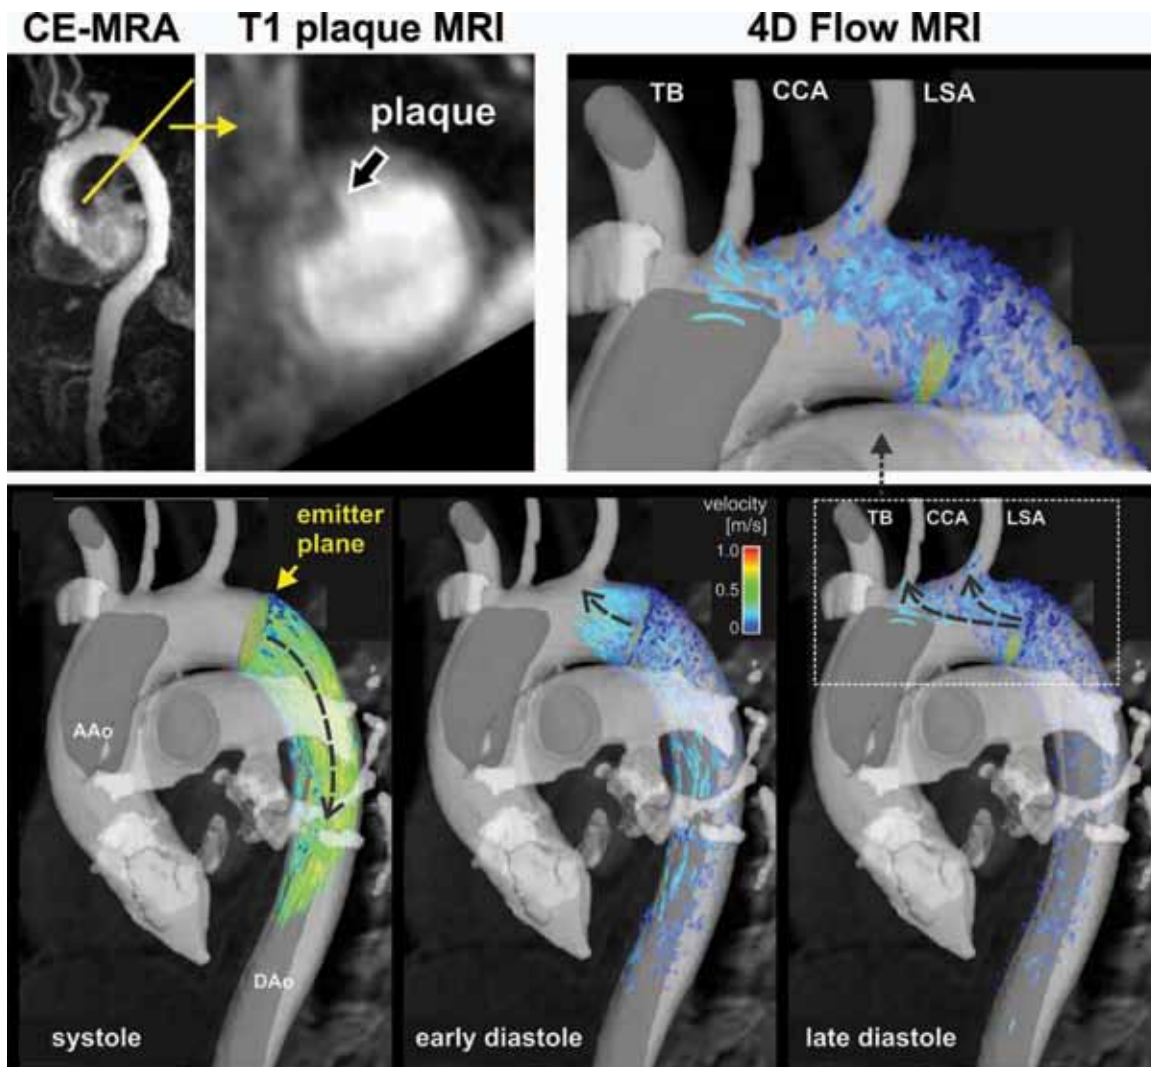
Top row: CE-MRA and 3D T1 plaque MRI used for detecting the location and size of aortic high-risk plaques. The plaque image shows a hypointense structure protruding into the proximal descending aorta (DAo) with a superimposed mobile thrombus ≥ 8 mm. CE-MRA indicates plaque localization. Lower row: An emitter plane positioned at the location of the aortic plaque was used to generate time-resolved 3D particle traces, which resemble the temporal and spatial evolution of blood flow throughout the cardiac cycle. The series of images show systolic forward flow followed by substantial diastolic retrograde flow. Marked diastolic retrograde flow originating from the location of the plaque in the proximal descending aorta is clearly evident and reaches two of three brain-feeding arteries. This mechanism thus indicates a risk for retrograde embolization in the brain stem and left hemisphere in the case of plaque rupture. (Image courtesy of Dr. M. Markl, Northwestern University, Chicago, IL.)
